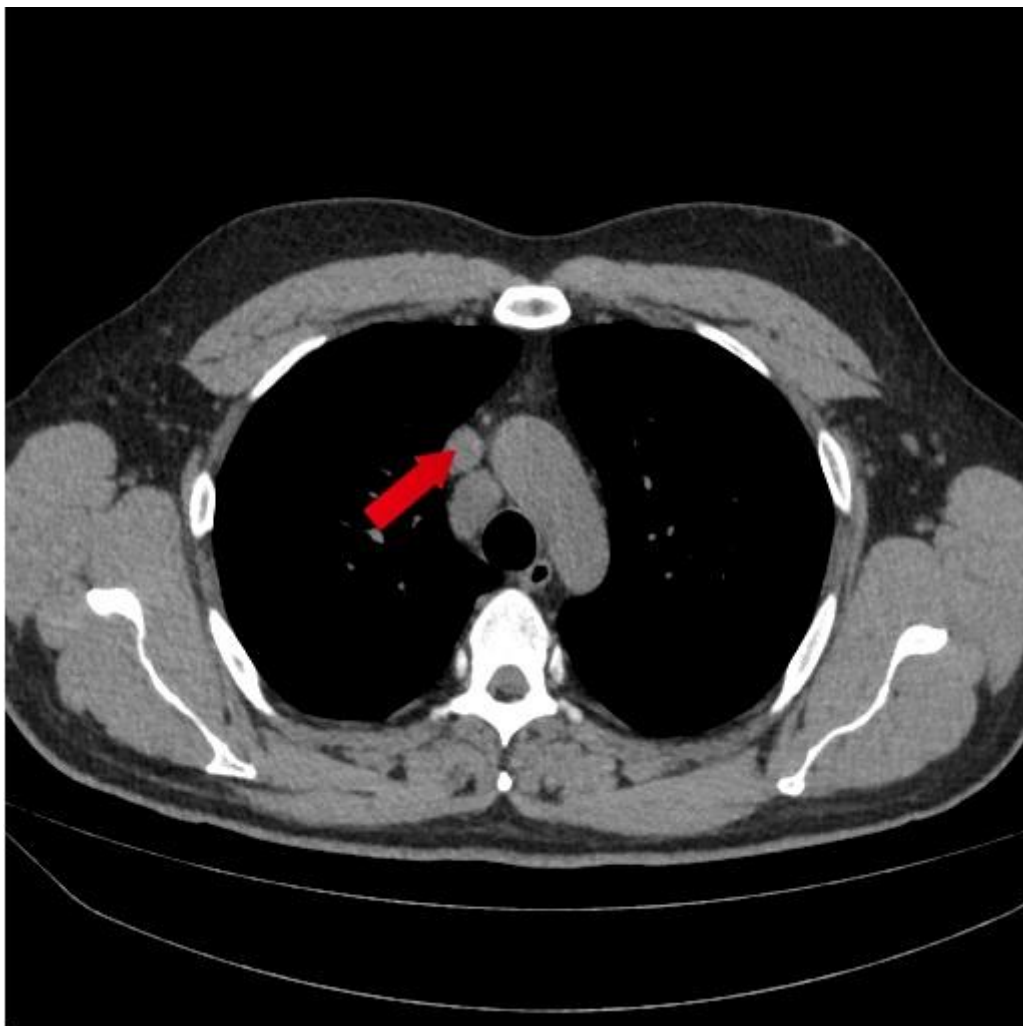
The computed tomography scan of a chest – enlarged lymph node near the aortic arch
